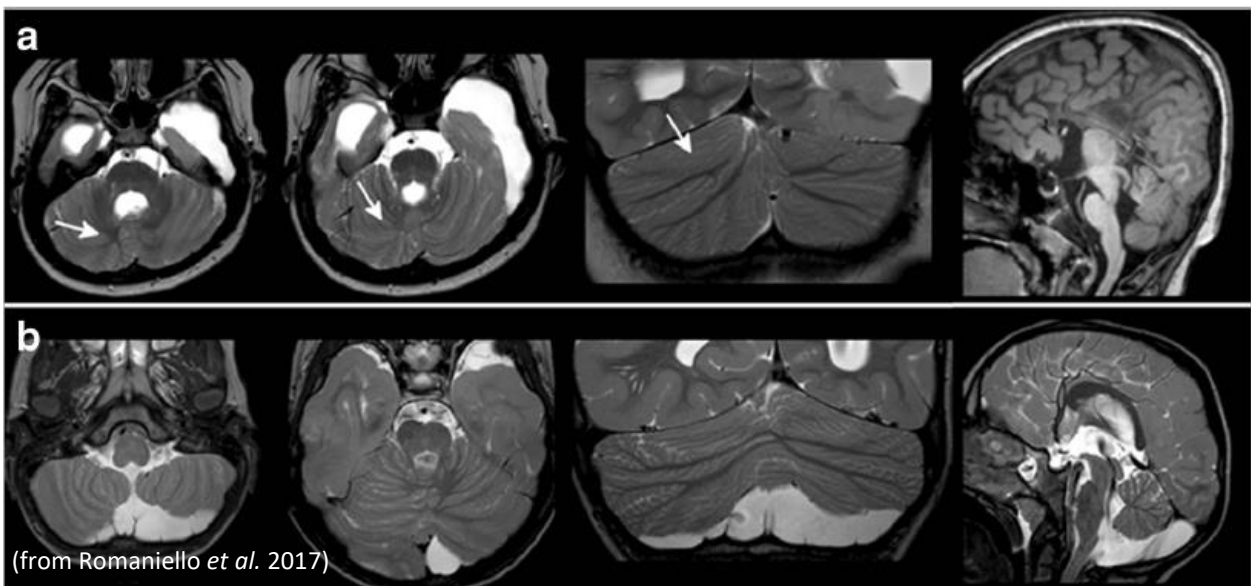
MRI findings in patients with mutations in TUBB2B gene. Representative MRI findings from two patients. (A) Right cortical cerebellar dysplasia involving the posterosuperior cerebellar hemisphere (arrows), small vermian, thin ponto-mesencephalic junction and corpus callosus agenesis (B) Normal cerebellum with supratentorial and brainstem involvement.
